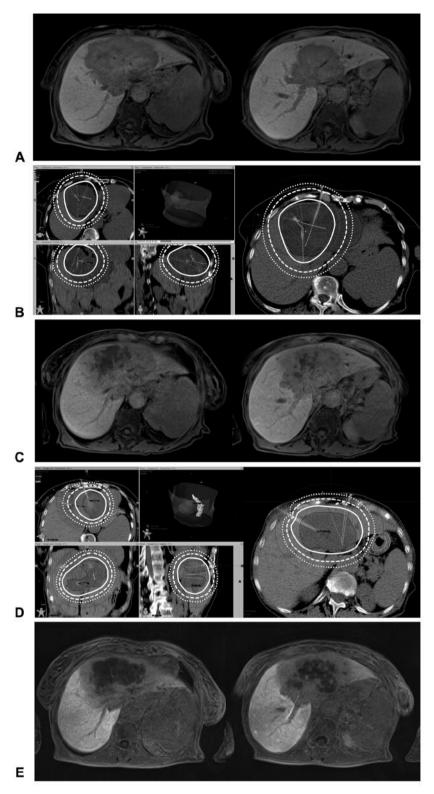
Planning and follow-up magnet resonance imaging (MRI) in hepatobiliary phase (left: cranial liver segments, right: caudal liver segments) and radiation plan (grey area = clinical target volume, white solid line 15 Gy, white dashed line 10 Gy, white dotted line 7 Gy): A) 1st pre-treatment MRI, B) 1st computed-tomography-guided high-dose-rate-brachytherapy (CT-HDRBT) of the upper tumor compartment, C) 2nd pre-treatment MRI reveals already therapeutic response of the 1st session after 1.5 months, D) 2nd CT-HDRBT of the lower tumor compartment, E) follow-up MRI shows local tumor control of the sequentially treated tumor 3.5 months after first ablation.
